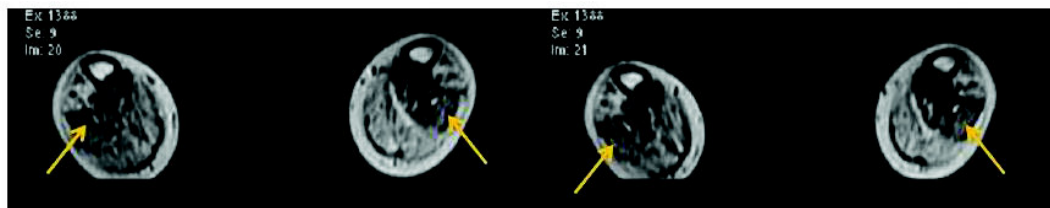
T1 Weighted Axial Musculoskeletal MRI image 24 months after cellular transplantation showing no reduction in muscle mass and no increase in fatty infiltration suggestive of halting of disease progression in Duchenne Muscular Dystrophy*
